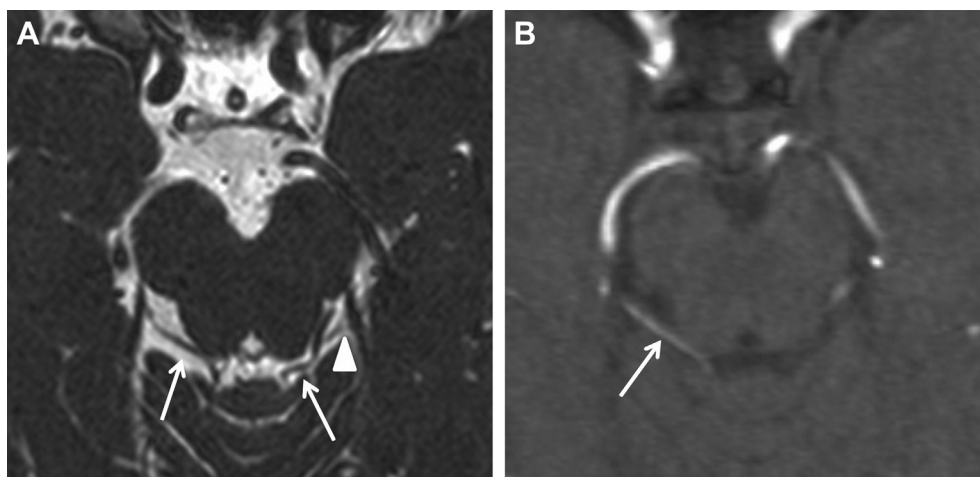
(A) Magnetic resonance imaging with fast imaging employing steady state acquisition (FIESTA) sequence, constructive interference in steady state (CISS) T2 image, in the subarachnoid area of the patient with SOM. The cut thickness was 0.9 mm (TE 5.47). The left trochlear nerve (arrowhead) and medial superior cerebellar artery (SCA) branches (arrows) can be seen. The right medial SCA is overlapped at the root exit zone and right trochlear nerve cannot be clearly distinguished from the artery on the right side. (B) One-mm cut, 3D transverse time of flight magnetic resonance angiogram (TE 7.2) confirmed that the structure at the root entry zone is an artery (arrow).
